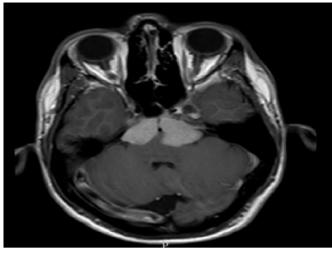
Cranial T1-weighted MR with contrast.
